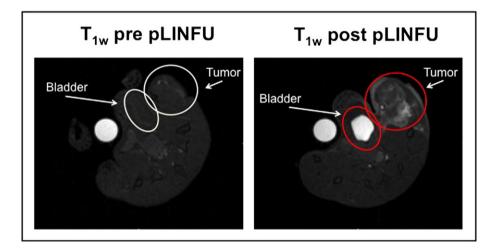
T_{1w}-MR images acquired before (left) and 40 min. after pLINFU application (right). The bright circled area is the reference tube used for the normalization of the contrast enhancement.
